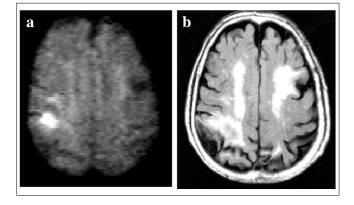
Patient with vascular dementia.* a Axial diffusionweighted image (DWI). b Axial T2 FLAIR image. The T2 FLAIR image shows diffuse white matter hyperintensity (leukoaraiosis) and a right parietal infarct. DWI reveals a small area of acute ischemia within the T2 hyperintensity, which is markedly hyperintense and located in the right parietal lobe
